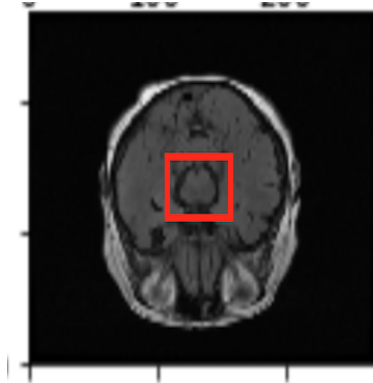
Slice of T2 axial MRI scan of Parkinson’s Disease patient highlighting the substantia nigra
